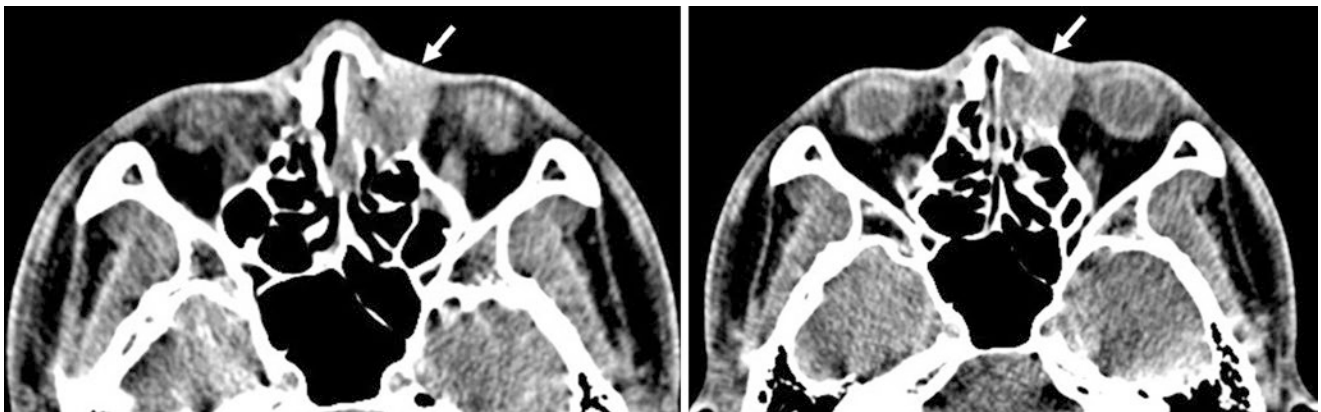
Axial non-contrast-enhanced CT images showing a soft tissue mass (white arrows) expanding the lacrimal sac fossa. There is demineralisation and remodelling of the adjacent bones
